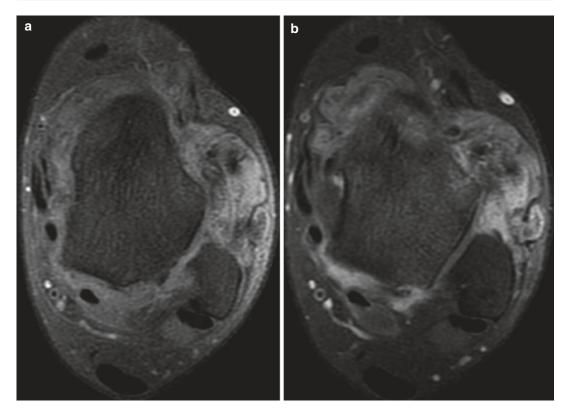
(a–b) Pigmented villonodular synovitis (*PVNS*) of the ankle. (a) Axial pre-contrast T1FS MR image. (b) Axial post-contrast T1FS MR image. Marked contrast enhancement of *PVNS* post-gadolinium is seen
